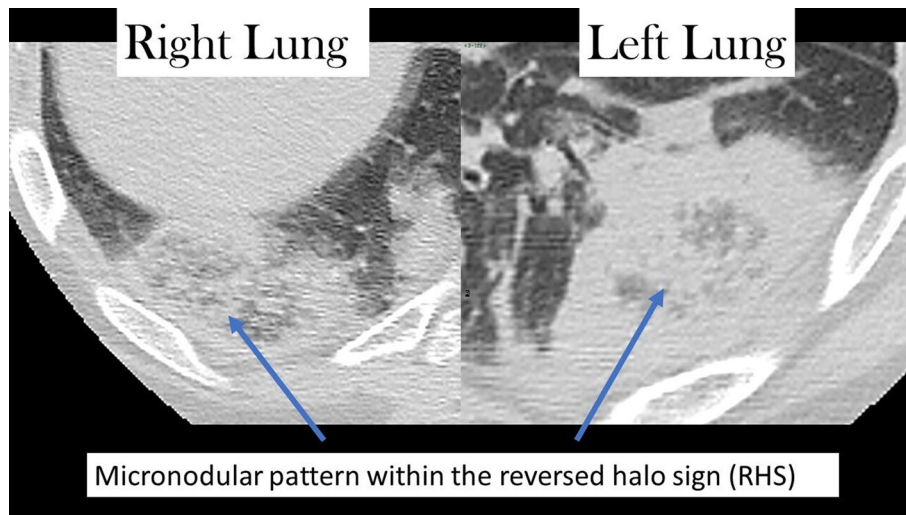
On the CT lung window, in both areas of RHS, a micronodular pattern is evident in the ground-glass opacity inside the pulmonary infarcted area on lung window CT images
